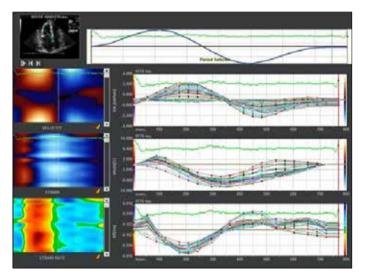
The color M-mode echocardiography map and time curves showing velocity, strain (%), and strain rates (1/s) in the apical four chamber view
